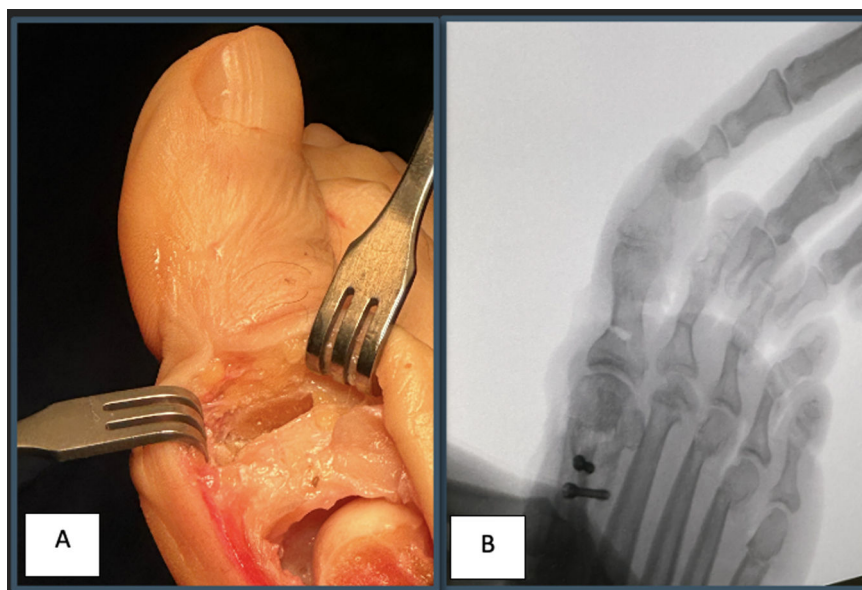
(A) Intraoperative image showing the AO after wedge removal, following osteoclasis. (B) Radiographic control showing the AO closed by osteoclasis.
